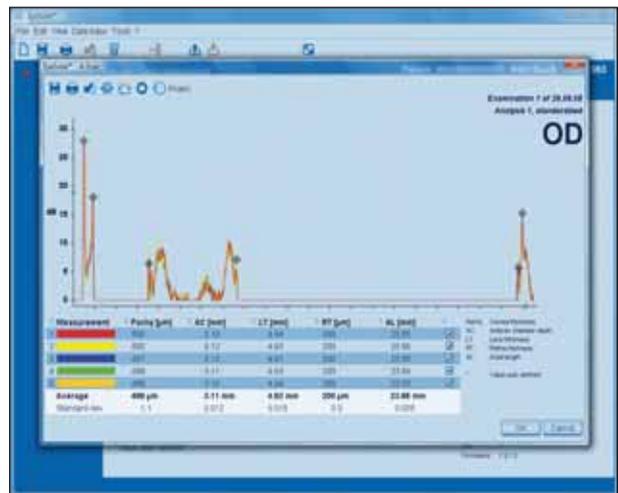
The LENSTAR LS900’s scans appear similar to immersion ultrasound, and all gates can be moved.
